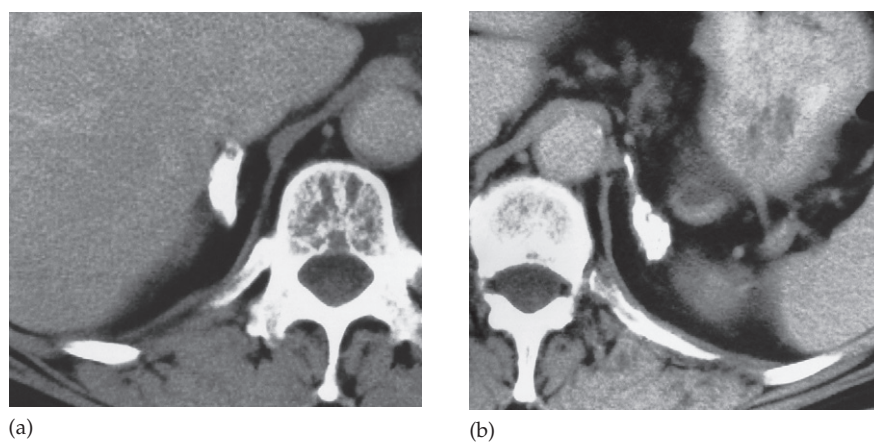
Adrenal calcification shown by CT. (a) Heavily calcified right adrenal gland. (b) Heavily calcified left adrenal gland.
